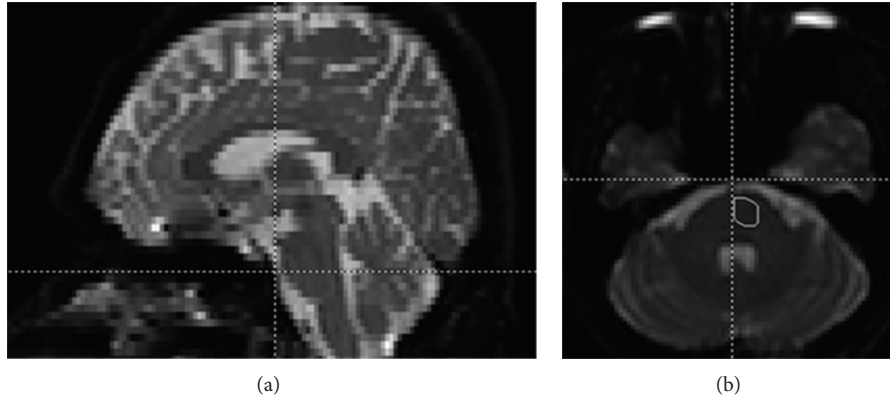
MRI data for the pons in the (a) sagittal and (b) axial planes. The rectangle in (b) was chosen as ROI to select the corticospinal tract (CST).
